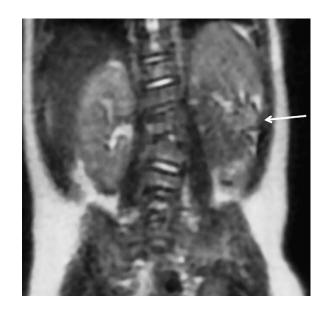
MRI, T2 SSFSE (Single shot fast spin echo) sequences. In this coronal view, an anatomic defect of the left kidney is evident, appearing rotated with the hilum (arrow) facing laterally.
